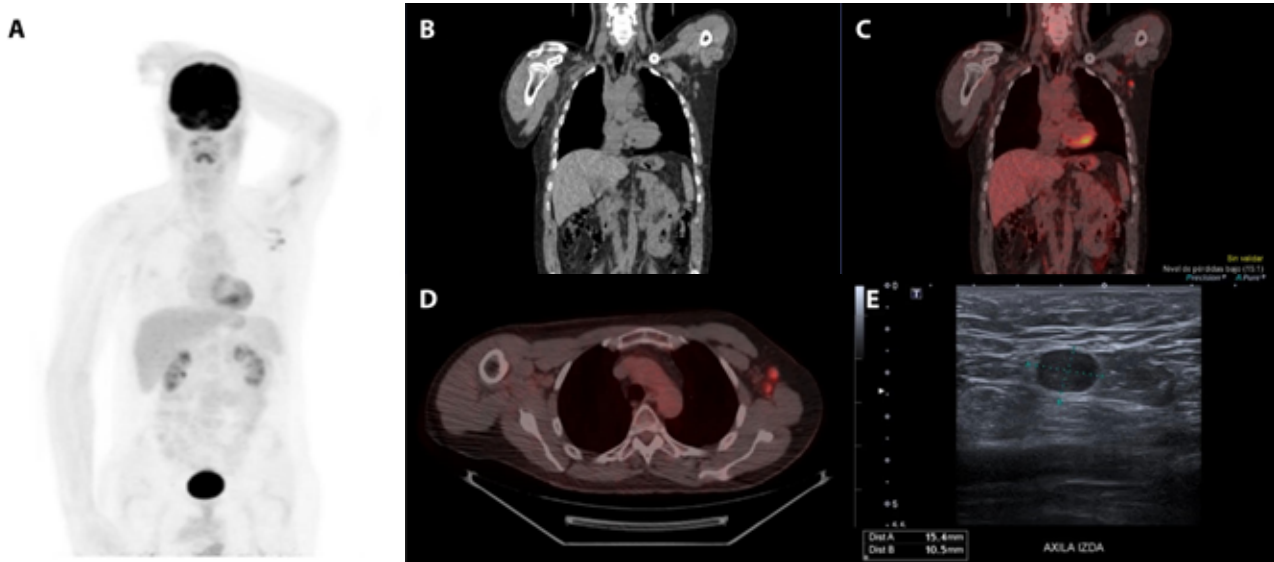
Imaging tests performed in May 2021. (A-D) Routine ^{18}F -FDG-PET/TC: hypermetabolic lymphadenopathy in the left axillary region, the largest and with most metabolism of 13 mm (SUVmax: 3.9), suggestive of malignancy. (E) Sonographic exam of the left axilla after PET/CT findings: left axillary lymphadenopathy of rounded morphology with displacement of the central fatty hilum at the expense of great hypoechoic cortical thickening, sonographically suspicious. Core needle biopsy was taken from it.
